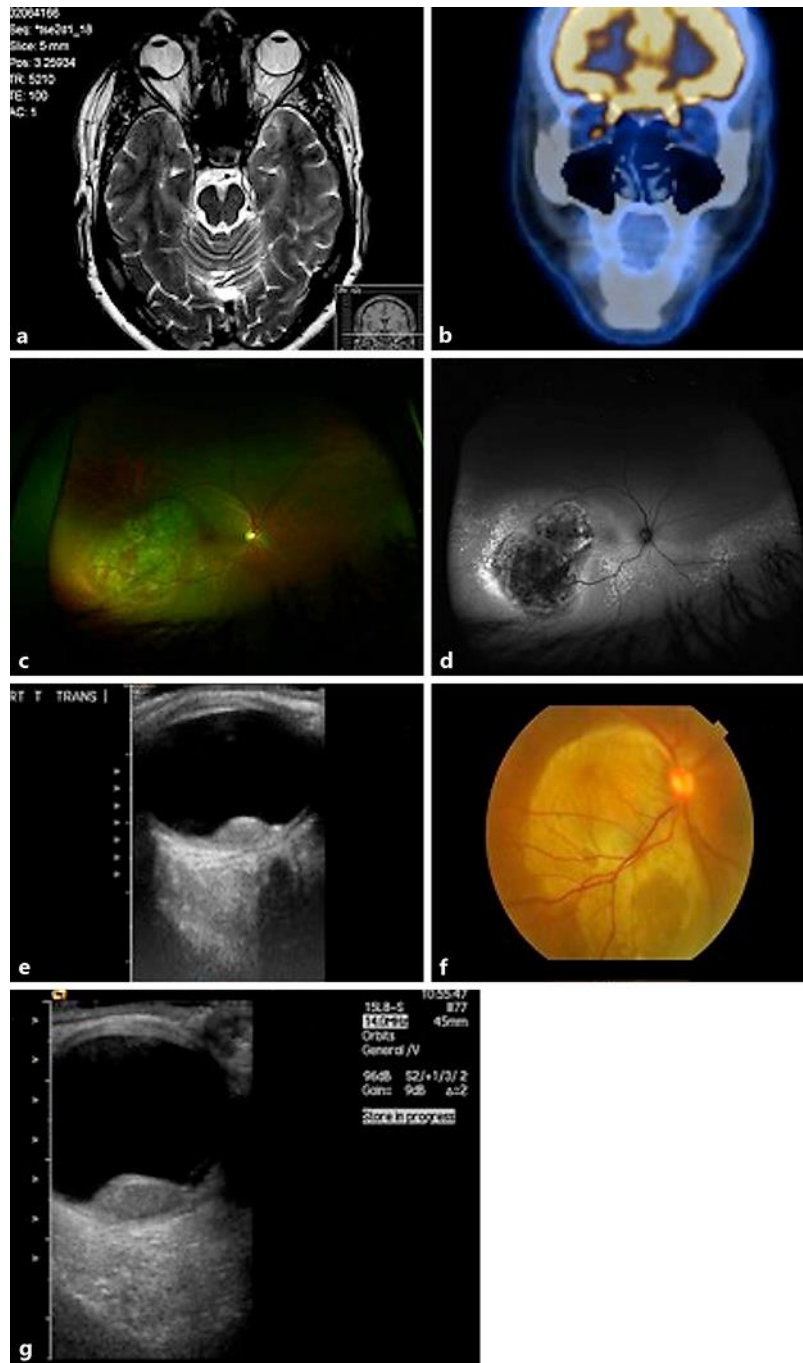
a Head MRI showing a solid, intraocular lesion in the right eye. b PET-CT showing uptake of the intraocular lesion in the right eye. c Colour fundus photograph of lightly pigmented, elevated choroidal lesion in the right eye. d Red-free fundus photograph of choroidal lesion in the right eye. e B-scan ultrasonography showing a hypoechoic lesion, measuring 3.4 mm in elevation. f Colour fundus photograph of a large, slightly pigmented choroidal lesion in the right eye. g B-scan ultrasonography showing a hypoechoic lesion, with an elevation of 5.7 mm.
